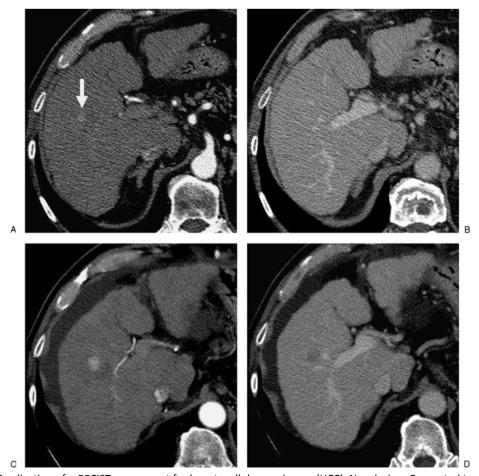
Application of mRECIST assessment for hepatocellular carcinoma (HCC). New lesion. Computed tomography (CT) scans obtained in an HCC patient's follow-up after treatment (main tumor not shown). On scans obtained at time point 1 (A, arterial phase; B, venous phase), a new lesion is identified (arrow). The tiny lesion is smaller than 1 cm; therefore, it must be considered equivocal. On CT scans obtained at time point 2 (C, arterial phase; D, venous phase), the tumor has become larger than 1 cm and shows the characteristic vascular pattern of HCC (arterial hypervascularization with venous washout). Although the criteria for diagnosing the lesion as HCC were fulfilled only at time point 2, progression must be declared in retrospect at time point 1, that is at the time the lesion was first detected.
